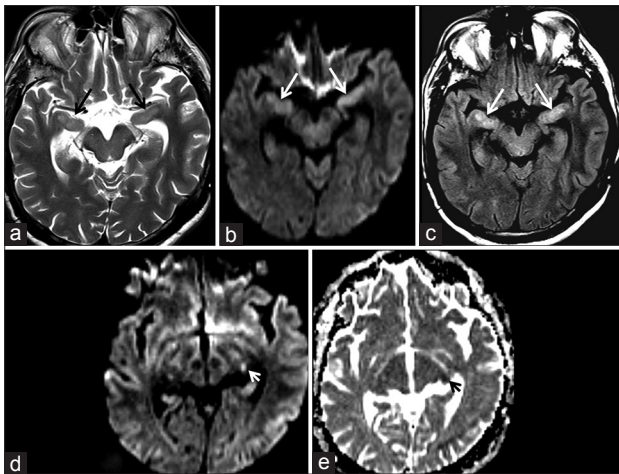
(a-c) Axial T2, DWI, FLAIR showing a hyperintensity in bilateral uncus (arrows). (d and e) diffusion restriction is seen in the left geniculate ganglion (arrows)
